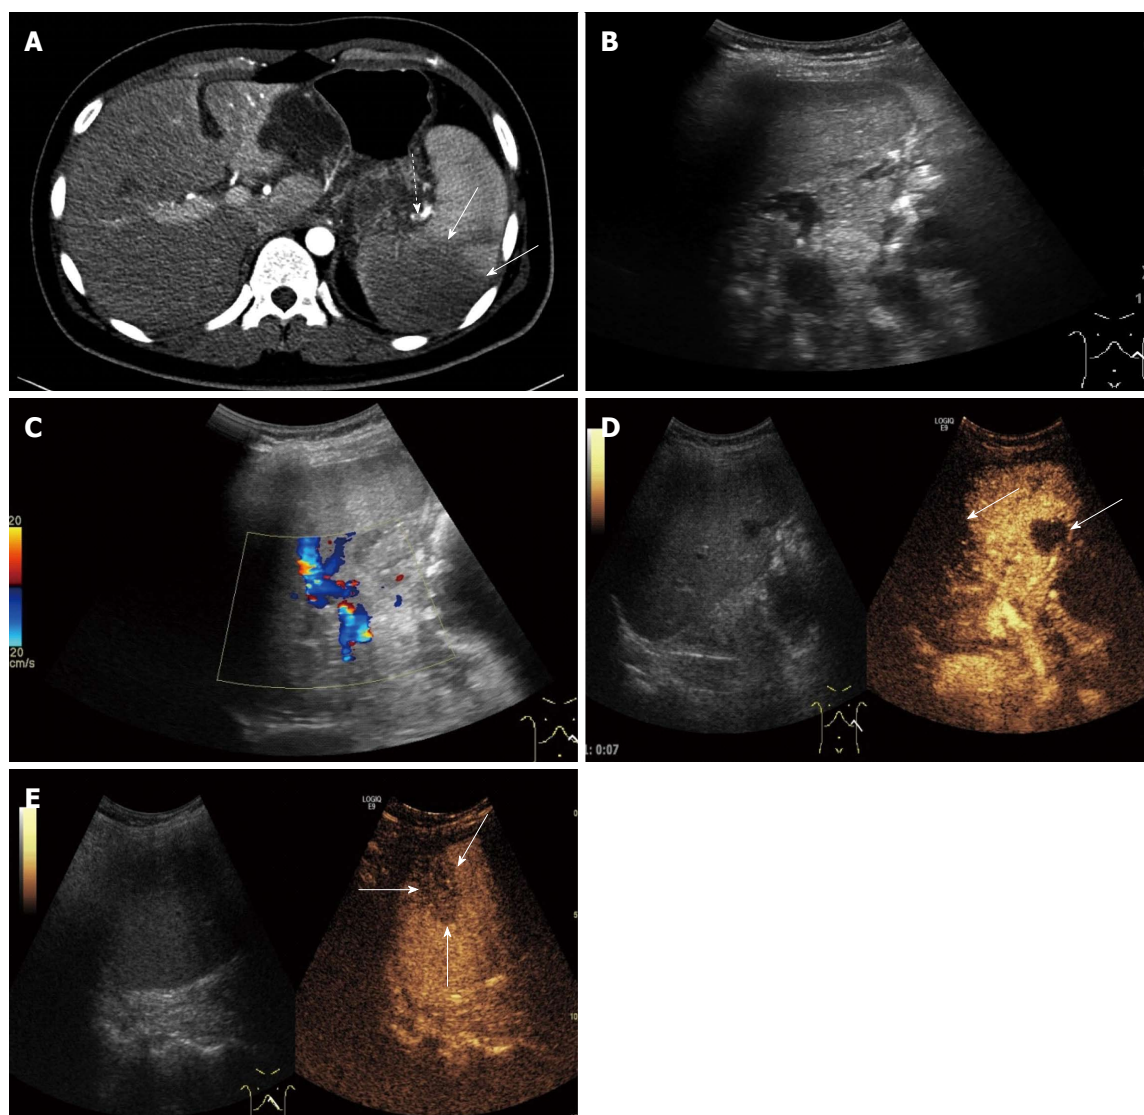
A 22-year-old man with splenic artery embolism. A: Enhanced-contrast computed tomography showing splenic artery embolism (dotted arrow), and the lesion of splenic infarction (solid arrow); B, C: Gray scale ultrasonography and color Doppler ultrasonography of the spleen showed no obvious lesion of splenic infarction; D: Some regions with no enhancement appeared in the splenic arterial phase (solid arrow) on contrast enhanced ultrasound (CEUS); E: A wedge-shaped splenic infarction with no enhancement was displayed in the splenic venous phase (solid arrow) on CEUS.
